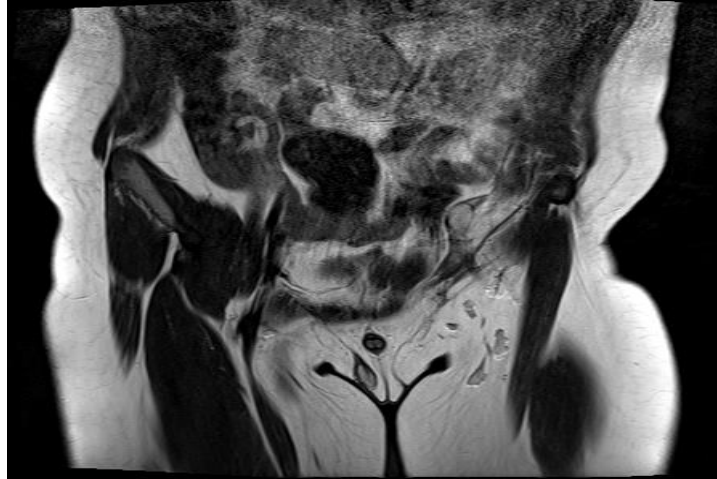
10 year old boy with intra-canalicular non-palpable undescended left testis, T1-weighted MR image shows isosignal testis.
